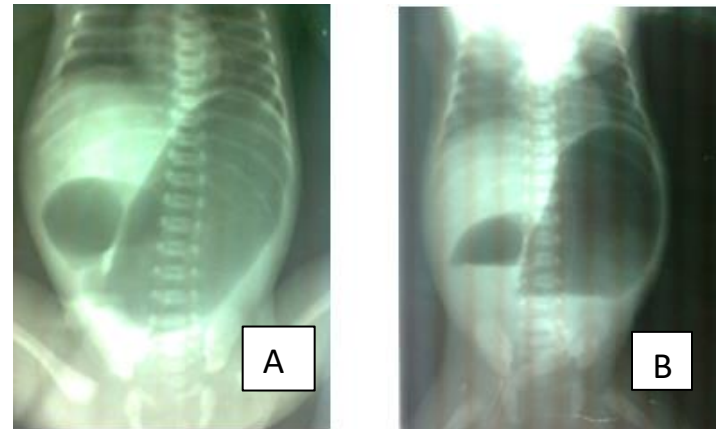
Plain abdominal radiographs showing the classical double bubble sign of duodenal atresia; A is supine view while B is erect view
